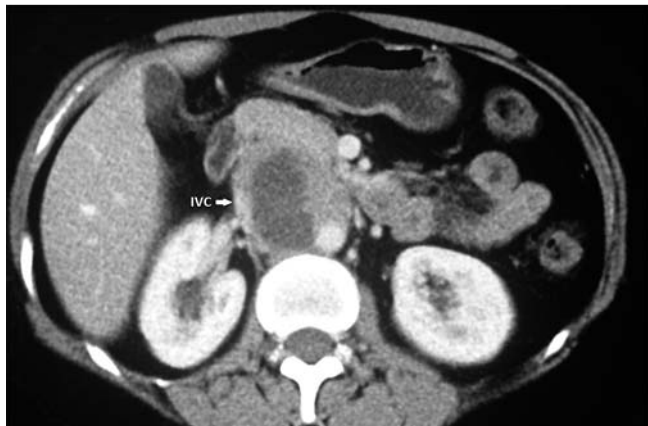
A repeat contrast enhanced CT abdominal scan showed a complex thick-walled cystic lesion measuring ~5 cm in size, located near the head of the pancreas and invading the medial wall of the inferior vena cava (IVC).
